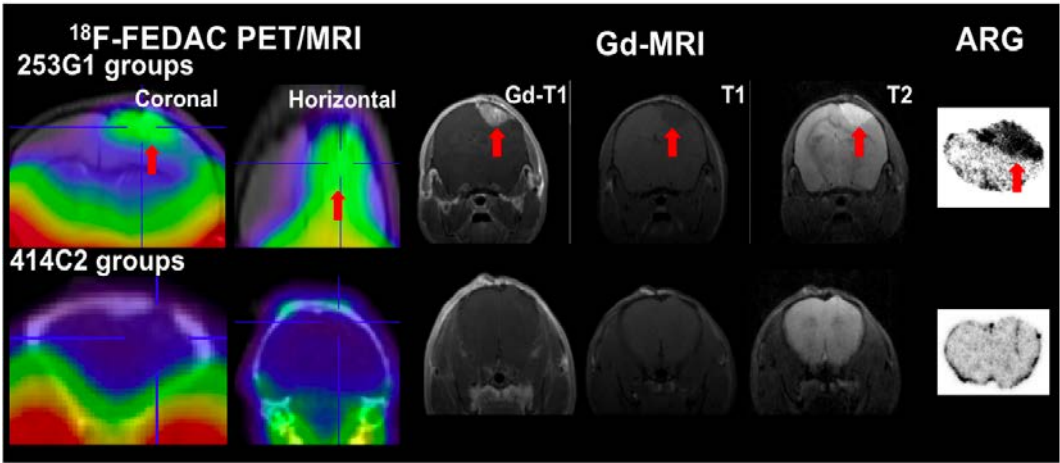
PET/MRI imaging of tumorigenicity of hiPSC-NS/PCs
